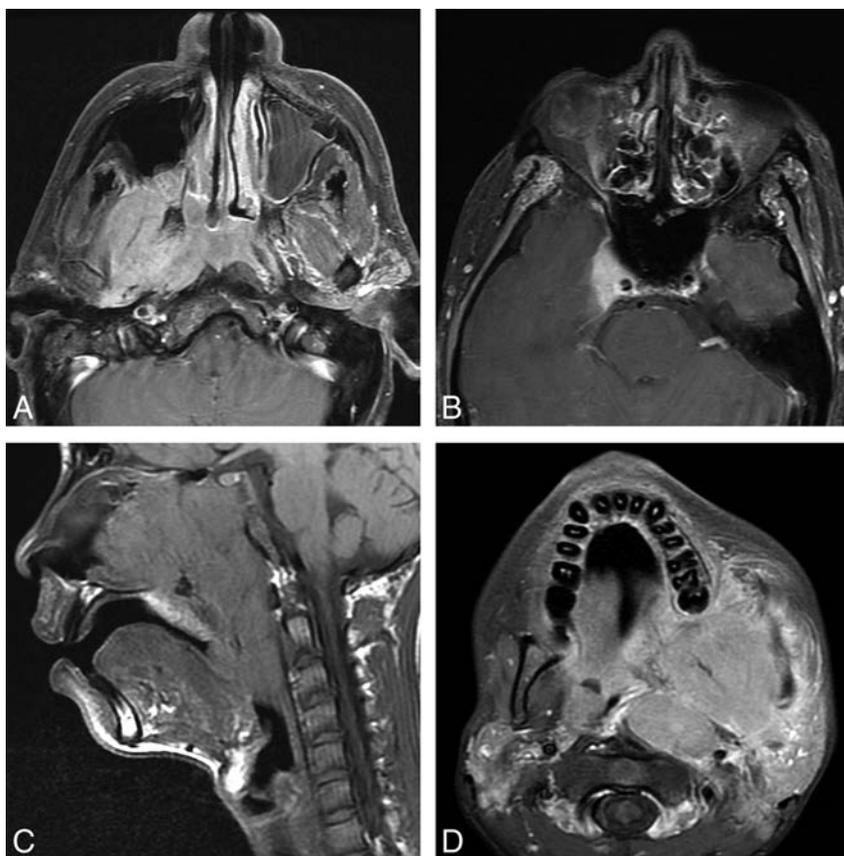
Two patients with nasopharyngeal carcinoma. *A* and *B*, A 64-year-old man with a nasopharyngeal mass found incidentally on PET/CT and determined to be EBV(+) undifferentiated nonkeratinizing carcinoma. Axial T1 postcontrast fat-saturated images (*A* and *B*) demonstrate an asymmetric nasopharyngeal mass with lateral extension to the right masticator space lateral pterygoid muscle. In the seventh edition, this would be T4 disease; however, in the eighth edition, this is only T2 disease. Note however that in this patient, there is also involvement of the pterygoid plates, which is now clarified as T3 disease, and superior extension to the right cavernous sinus, which is T4 disease in both *AJCC Cancer Staging Manual* seventh and eighth editions. *C* and *D*, A 15-year-old boy presenting with epistaxis and a large mass arising from the nasopharynx determined to be EBV(+) undifferentiated nonkeratinizing carcinoma. Sagittal T1 (*C*) shows the large mass filling the nasopharynx, extending inferiorly to the oropharynx and anteriorly to the nasal cavity. Axial postcontrast T1 with fat saturation (*D*) shows lateral extension of the mass into the masticator space but also to the left parotid gland. In the eighth edition, involvement of the parotid gland or extension of tumor beyond the lateral surface of the lateral pterygoid muscle determines T4 status.
